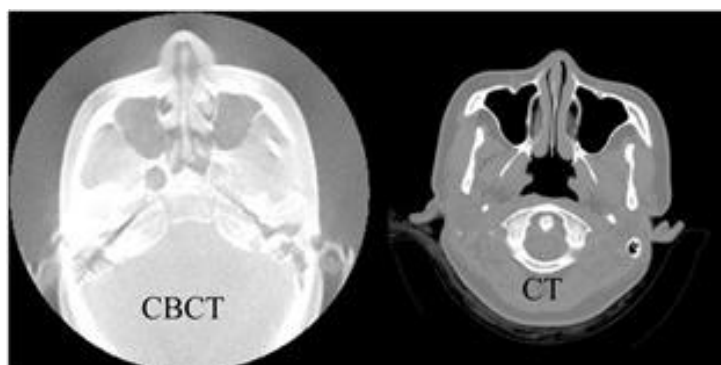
Typical CBCT vs. CT image in which appear the poor tissue contrast of CBCT (Kabaliuk *et al.*, 2017).
